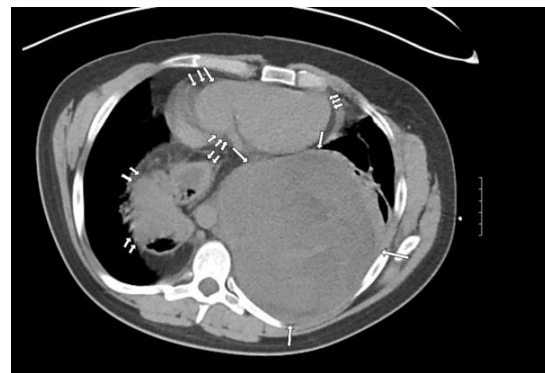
Axial non-contrast chest CT in a soft tissue window. A large intrathoracic, extrapulmonary mass is visualized compressing the heart anteriorly (single arrow). A hiatal hernia is incidentally noted within the right thoracic cavity, containing abdominal contents such as stomach and colon (double arrows). The heart is
